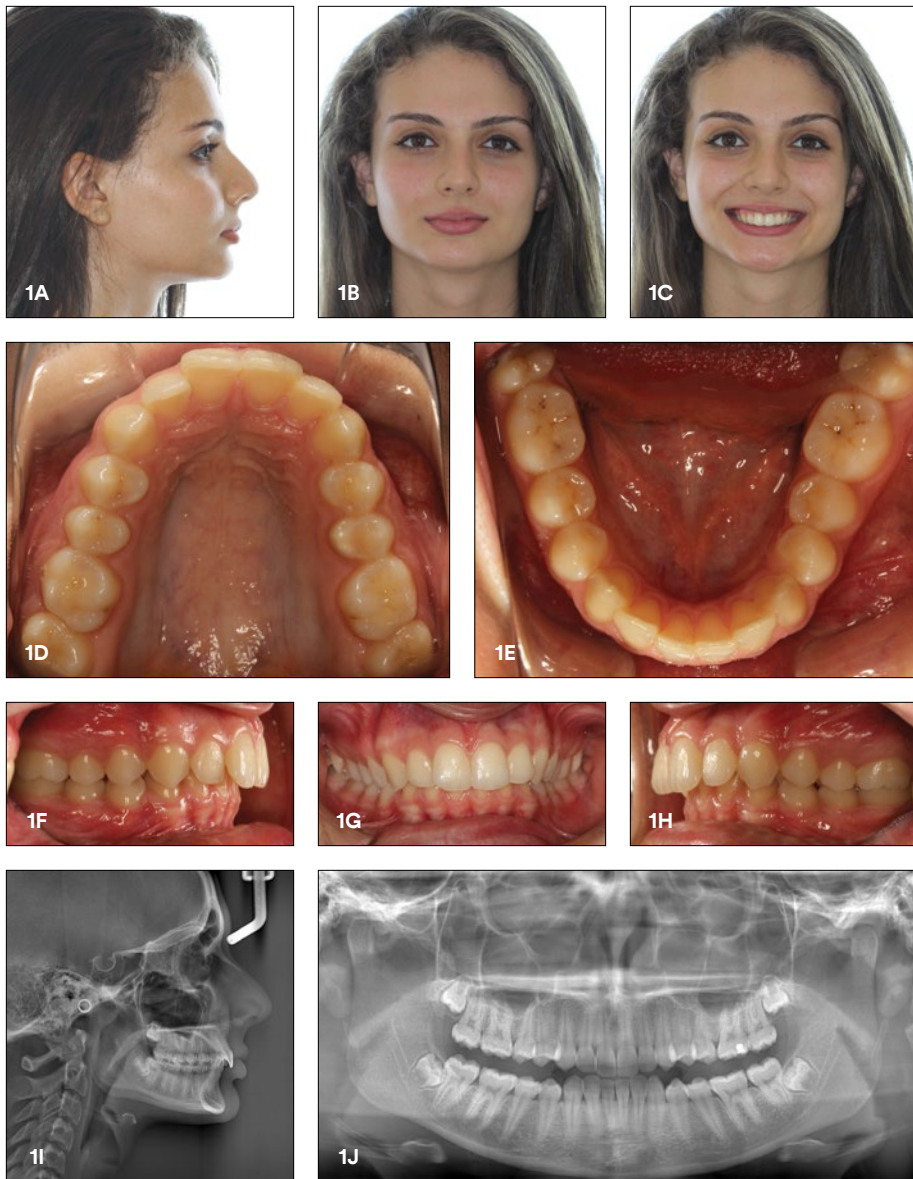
Pretreatment photos and radiographs.
